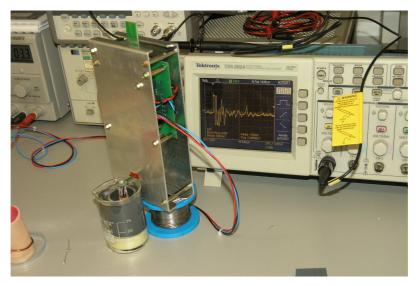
rev 1 board with ultrasound sensor array mounted, during preliminary electrical tests.
